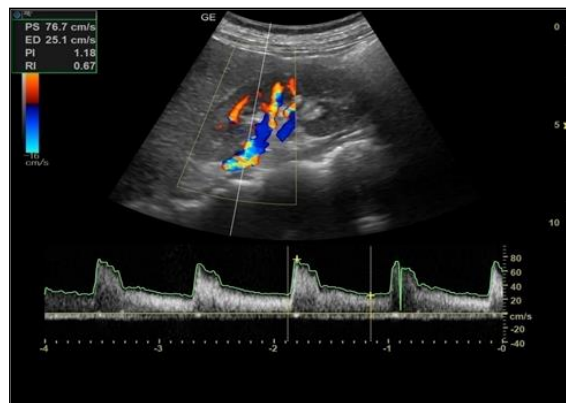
RI- 0.67 Doppler image
